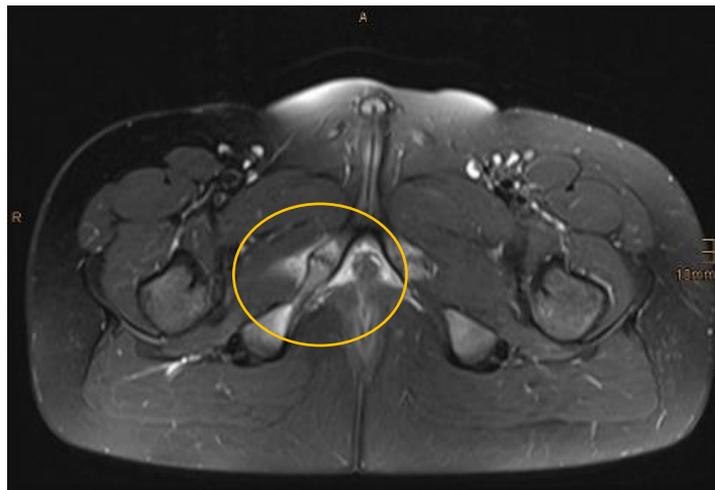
MRI of the pelvis.
